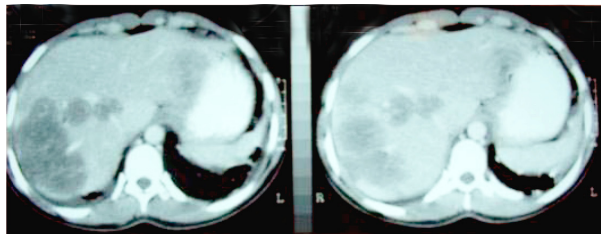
Computed tomography scan showing liver nodules and masses
